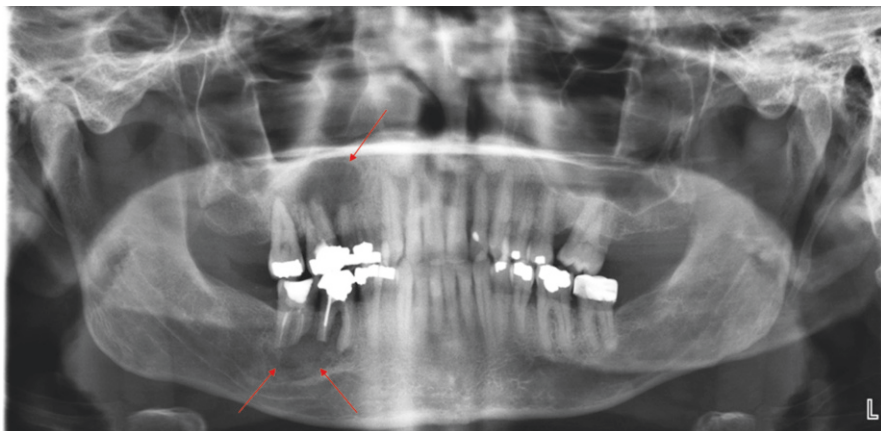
Panoramic radiograph of a 31-year-old male patient with giant cell tumors of the right maxilla and mandible (*arrows*). The lesions are associated with root resorption of the adjacent teeth
